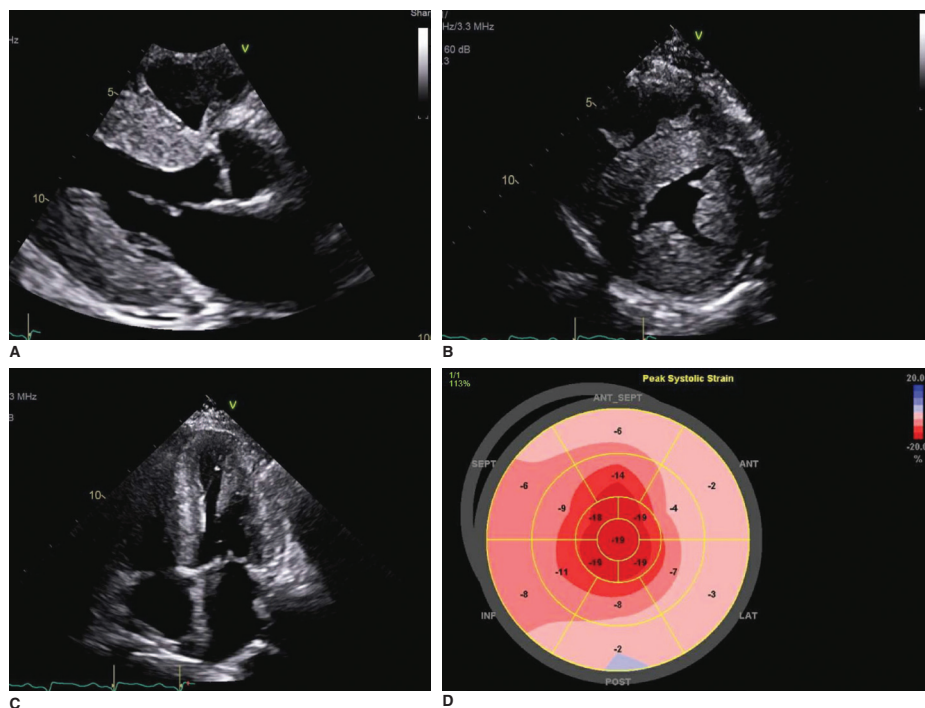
Characteristic two-dimensional echocardiographic images of cardiac amyloidosis in (A) parasternal long axis, (B) parasternal short axis, and (C) apical four chamber views notable for concentric left ventricular wall thickening and a “scintillating” myocardium. (D) Characteristic strain bull’s eye plot showing a relative apical sparing pattern.
